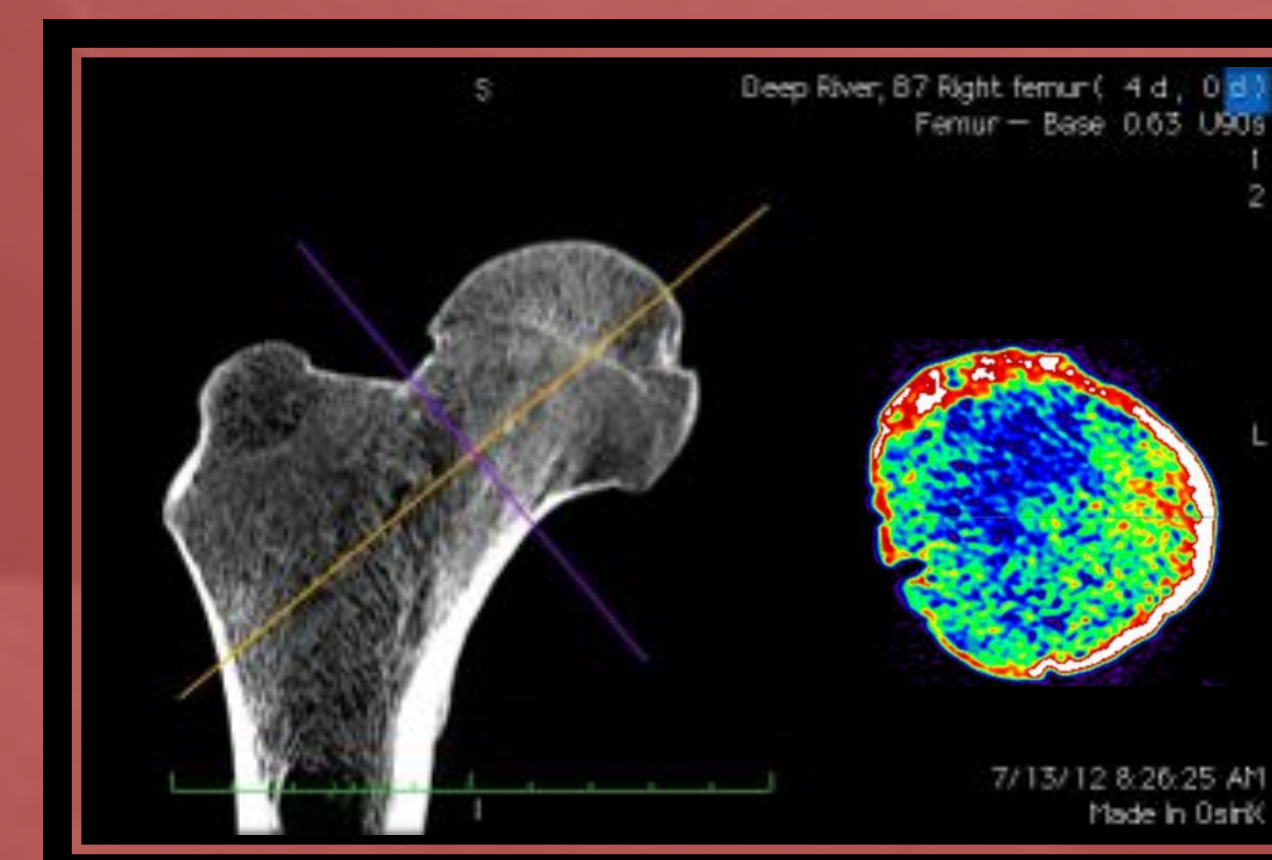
CT scan of a femoral neck with high bone density. The white, red, yellow, and green regions are more dense than the blue region. CT imagery by Dr. Bruno Frohlich.
